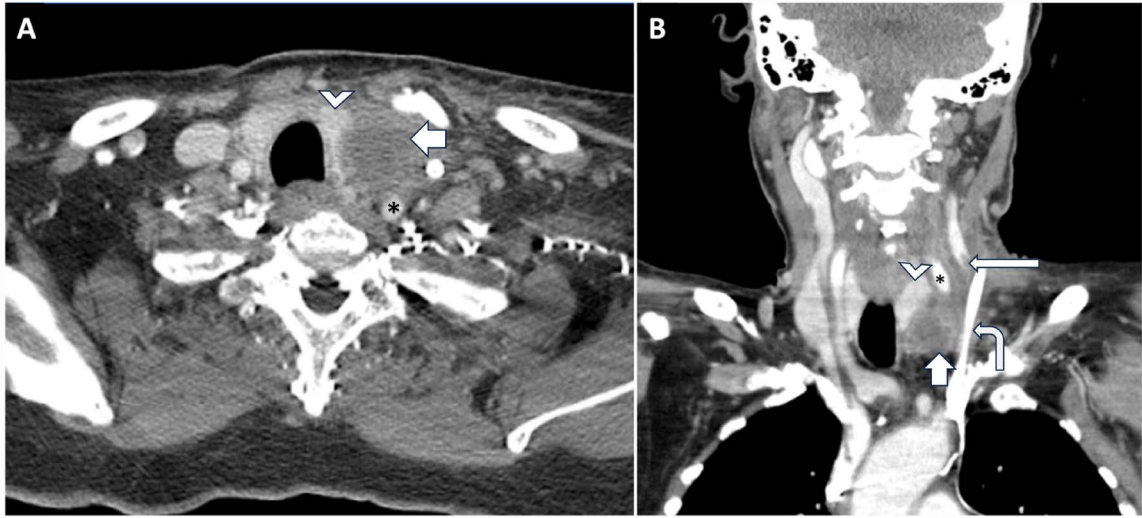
Axial (A) and coronal (B) contrast-enhanced computed tomography (CT) demonstrate a 3 x 3.1 x 3.2 cm irregular, necrotic mass (short arrow) abutting the inferior pole of the left thyroid lobe (arrowhead) and ipsilateral carotid sheath structures causing posterior displacement of the left common carotid artery (asterisk). Note the central venous catheter within the left internal jugular vein (bent arrow). A filling defect is seen consistent with a jugular vein thrombus (thin arrow).
